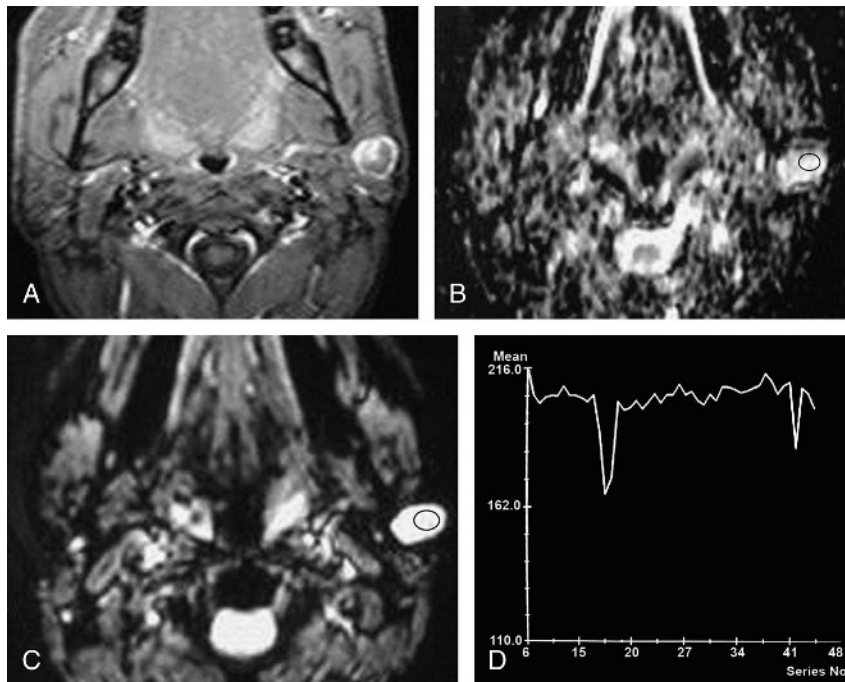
Pleomorphic adenoma. A, Axial contrast enhanced T1-weighted image shows enhancing mass in the superficial lobe of the left parotid gland. B, Axial ADC map shows unrestricted diffusion of the tumor with ADC value of $1.75 \times 10^{-3} \text{ mm}^2/\text{s}$. C, Axial susceptibility perfusion-weighted MR image shows the ROI of the lesion, D, Time signal intensity curve shows the DSC% of the parotid tumor is 18.6%.
